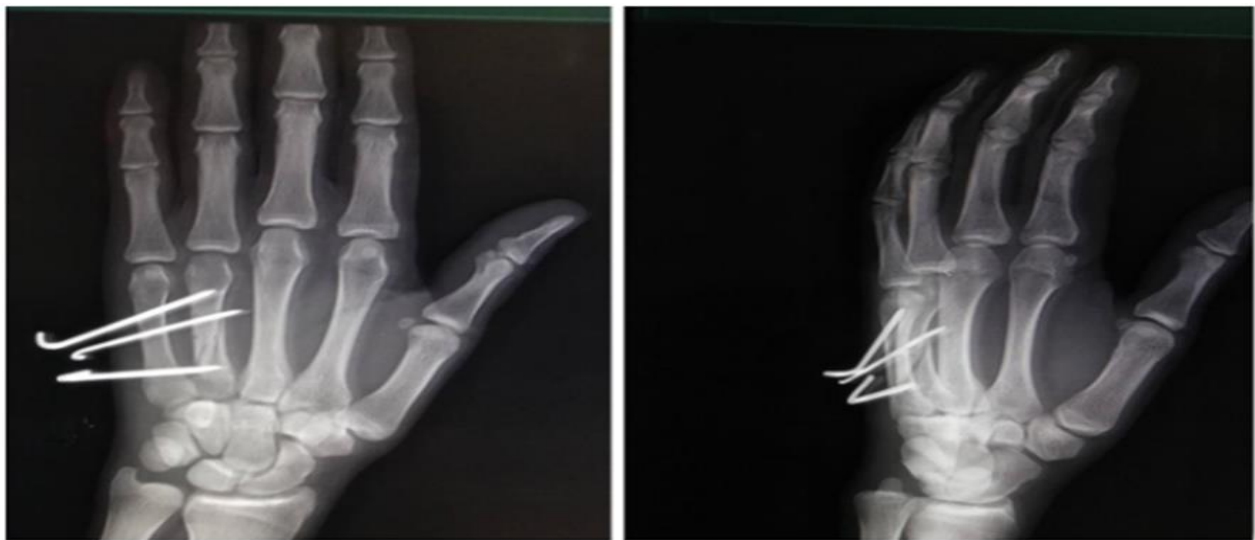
Late follow-up at the 4th week postoperative X-ray P/A & oblique views that show a stable uniting fracture.
